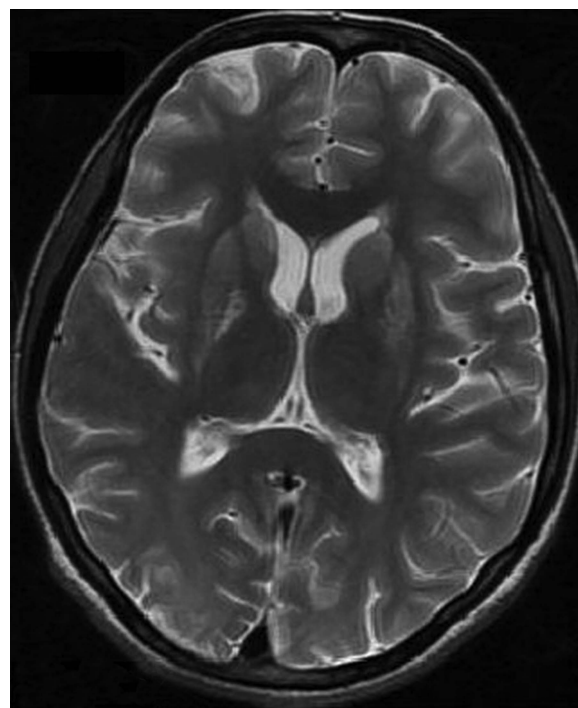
Follow-up (after 4 weeks) MRI of the brain with T2-weighted sequence showing a significant resolution of basal ganglia lesion.
